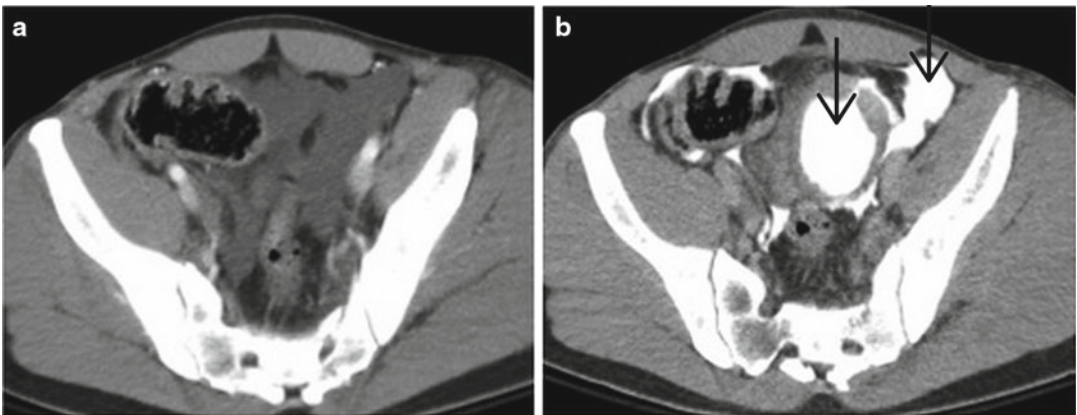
CT cystography of an intraperitoneal bladder injury. (a) Free fluid in paracolic gutters and cul de sac outlining bowel (*arrows*). (b) Note opacification of free fluid during cystogram (*arrows*) (images courtesy C. Menias)
